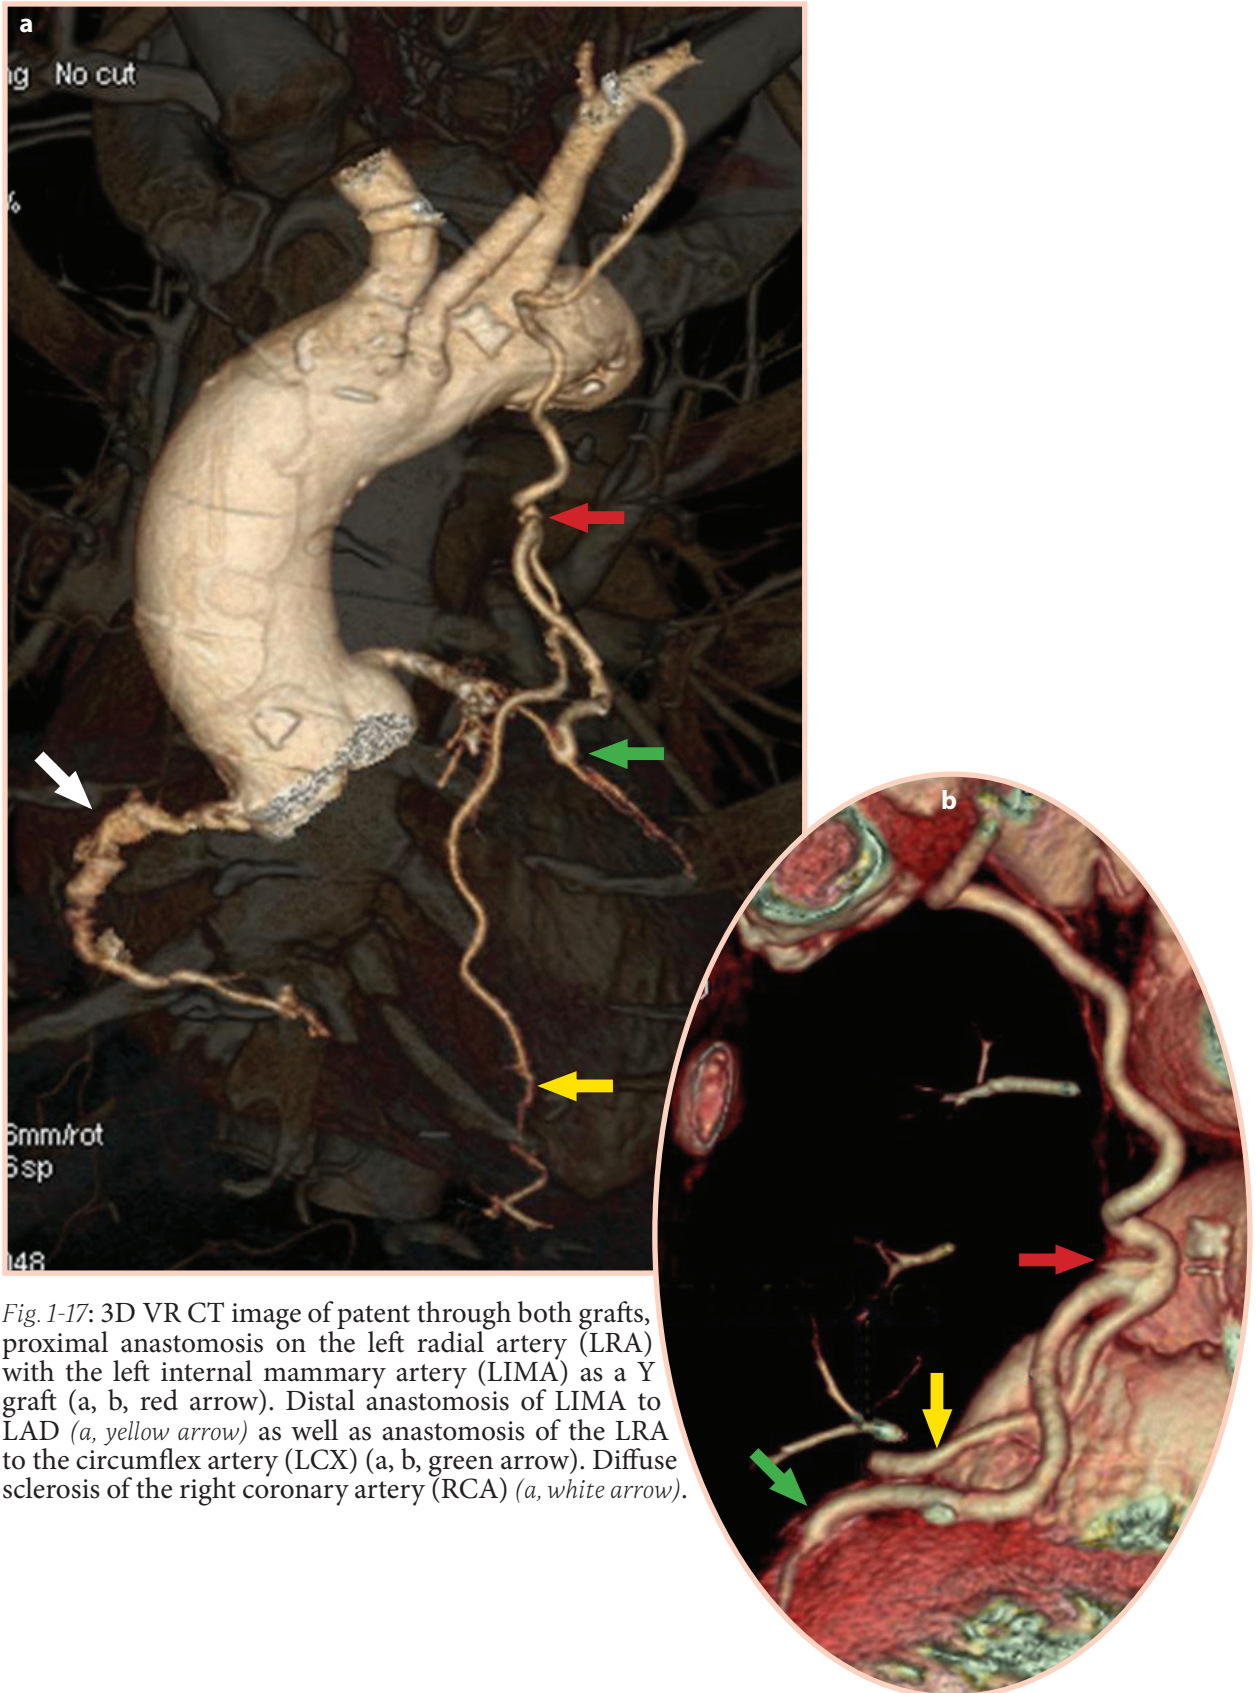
3D VR CT image of patent through both grafts, proximal anastomosis on the left radial artery (LRA) with the left internal mammary artery (LIMA) as a Y graft (a, b, red arrow). Distal anastomosis of LIMA to LAD (a, yellow arrow) as well as anastomosis of the LRA to the circumflex artery (LCX) (a, b, green arrow). Diffuse sclerosis of the right coronary artery (RCA) (a, white arrow).
